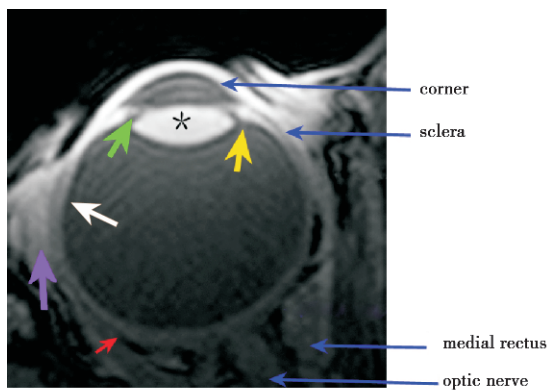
Axial FFE sequence T₁WI HR-MR image .The layers of the globe wall are depicted, as well as pars plicata (yellow arrow), iris (green arrow), retina (white arrow) Tenon's capsule (red arrow), Lacrimal-gland (purple arrow), lens (asterisk).
